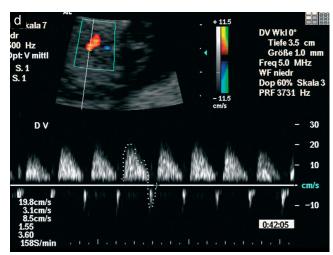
Doppler examination in a fetus with trisomy 18, tetralogy of Fallot with absent pulmonary valve syndrome and patent ductus arteriosus at 10 + 3 weeks' gestation (Case 3). Reversed flow during diastole is demonstrated in the descending aorta (a), middle cerebral artery (b) and umbilical artery (c), and reversed flow during atrial contraction is demonstrated in the ductus venosus (d).
